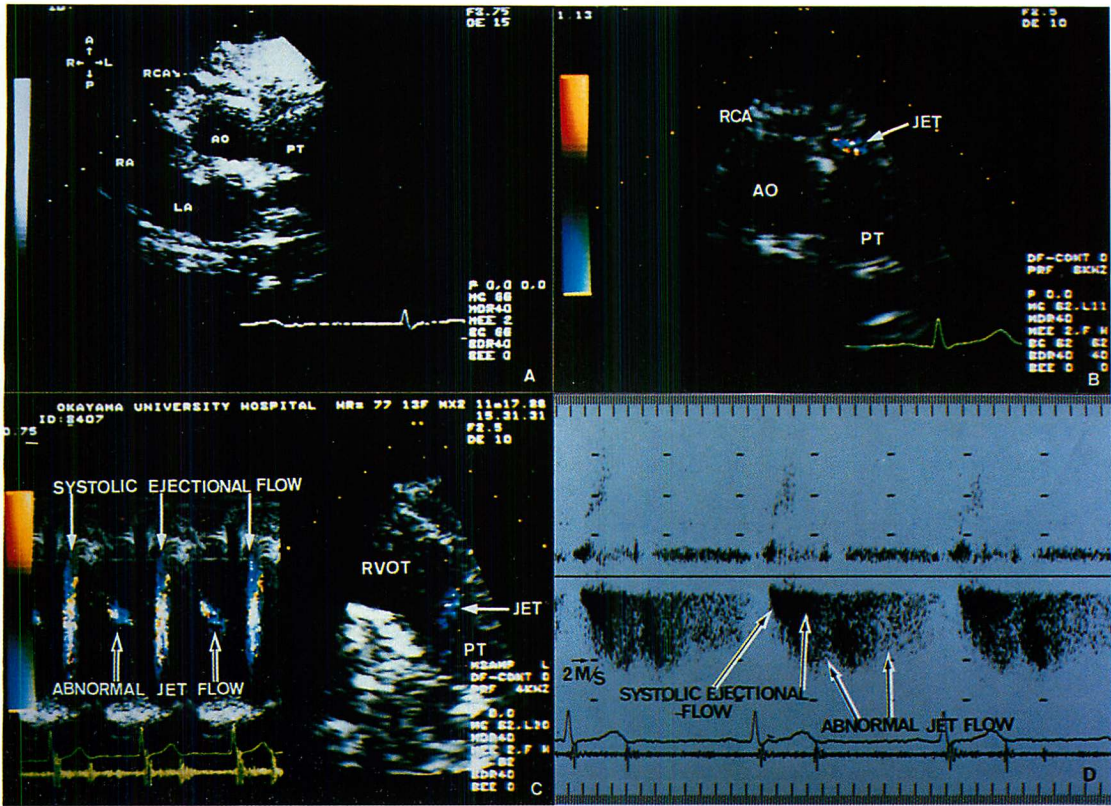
Echocardiographic findings.
